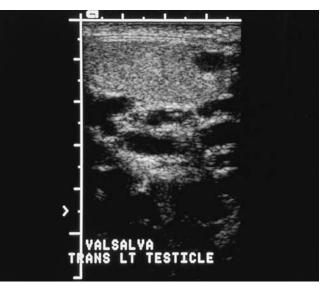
Transverse sonogram of the inferior border of the left scrotum.
